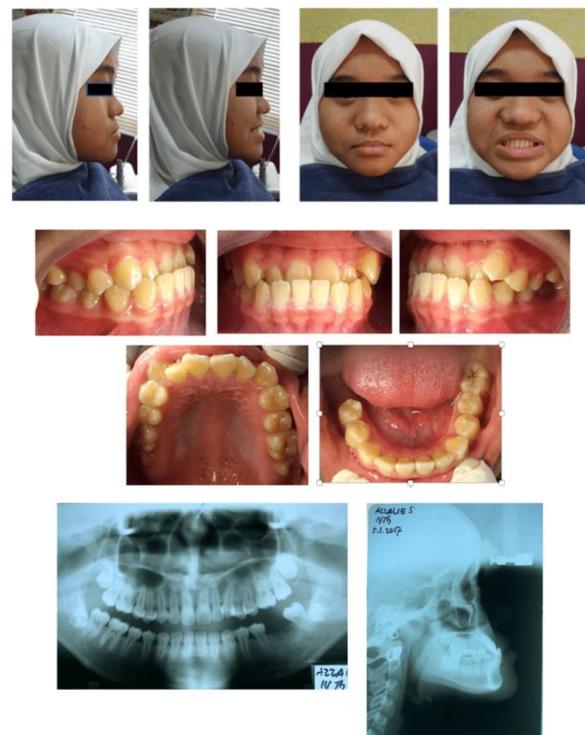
Extra-oral, intra-oral, and pre-treatment radiographs (case 1)
